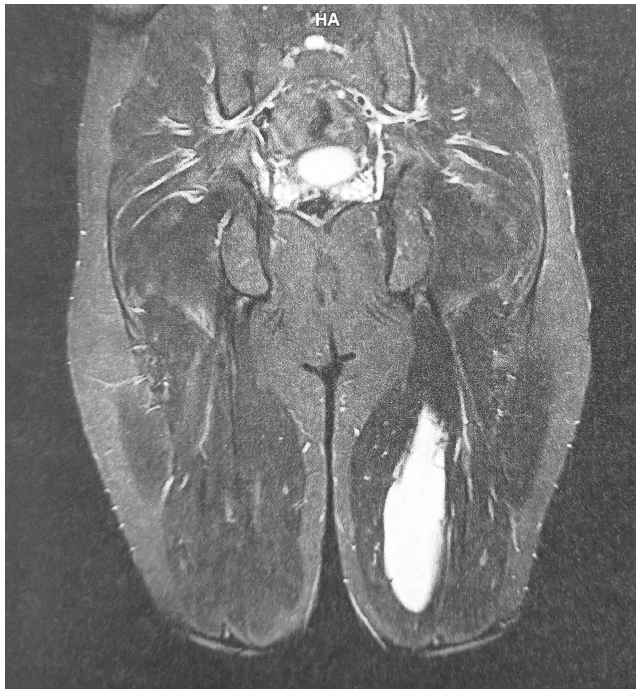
Magnetic resonance imaging (MRI) revealed a distinct abnormal signal area in the posteromedial compartment of the left thigh. The observed lesion predominantly exhibited a cystic nature, measuring 16 cm along its major axis and 5 cm in the transverse plane. It displayed a hyperintense signal on T2-weighted sequences.
